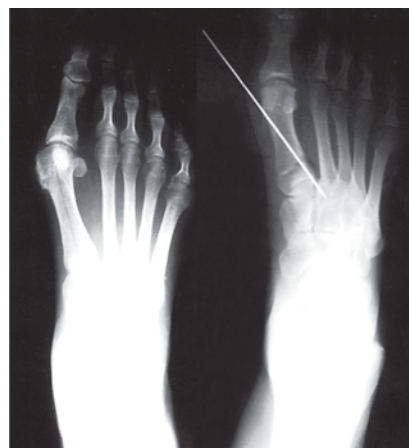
Pre- and postoperative X-ray images
